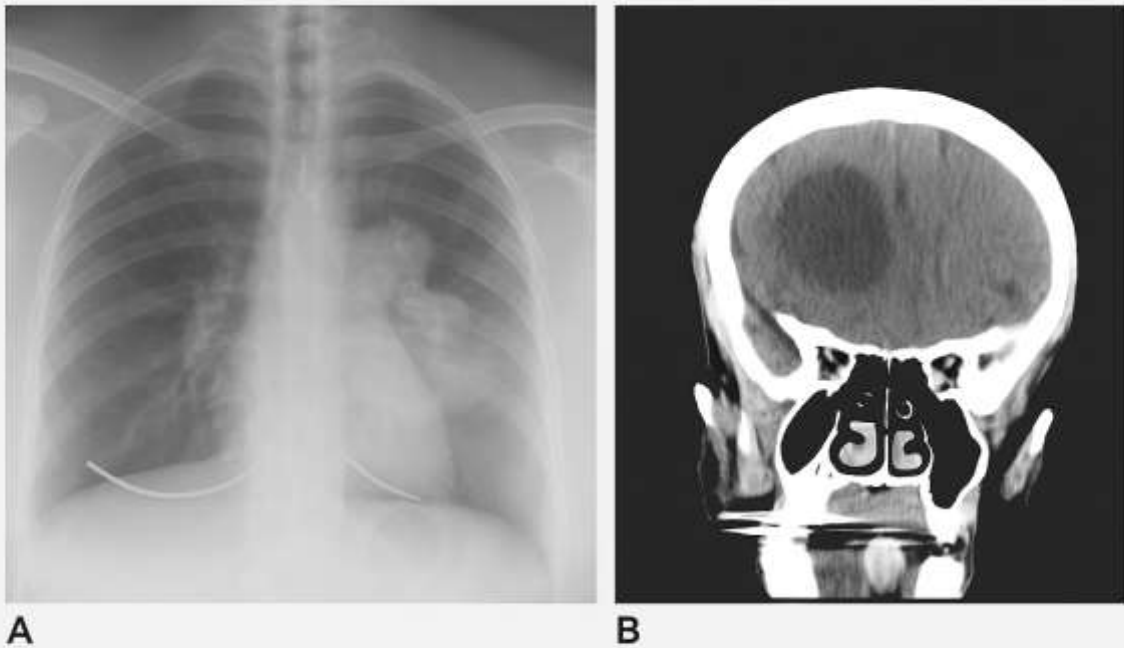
(A) Chest X-ray showing a large left-sided pulmonary mass. (B) Coronal brain CT demonstrating a metastatic lesion in right frontal lobe.
